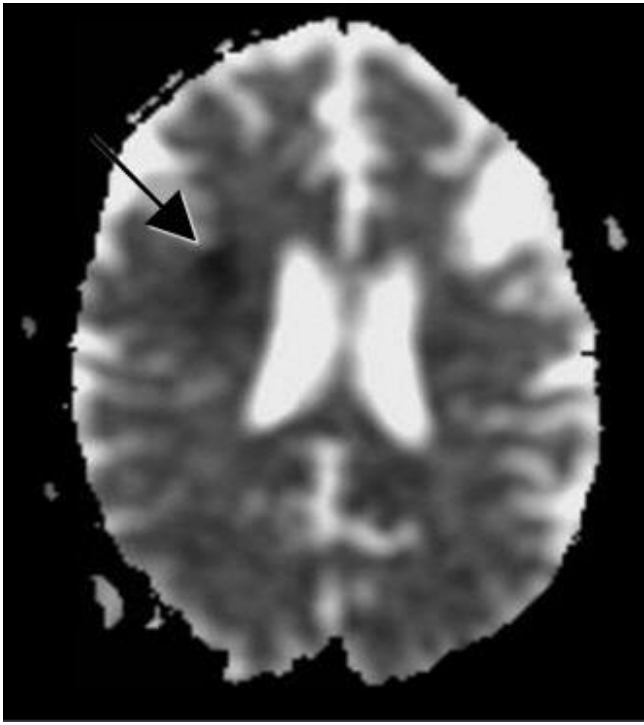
Brain MRI without contrast (ADC map): Showing infarct in right frontal lobe (arrow).
